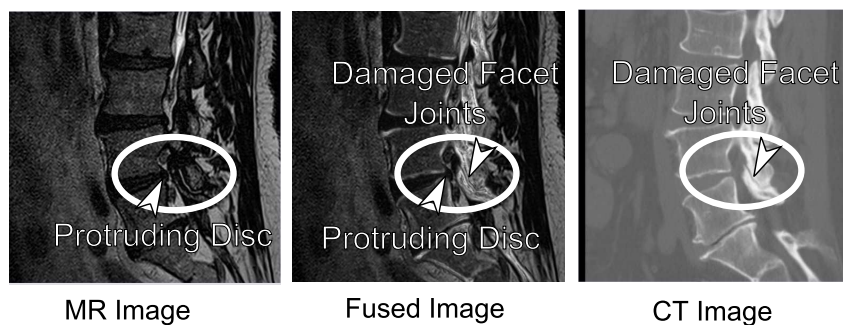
Images of damaged spine: left - MR showing a protruding disc (hypointense region); middle - Fused image showing the disc, the spinal cord and the damaged facet joints; right - CT image showing damaged facet joints.
